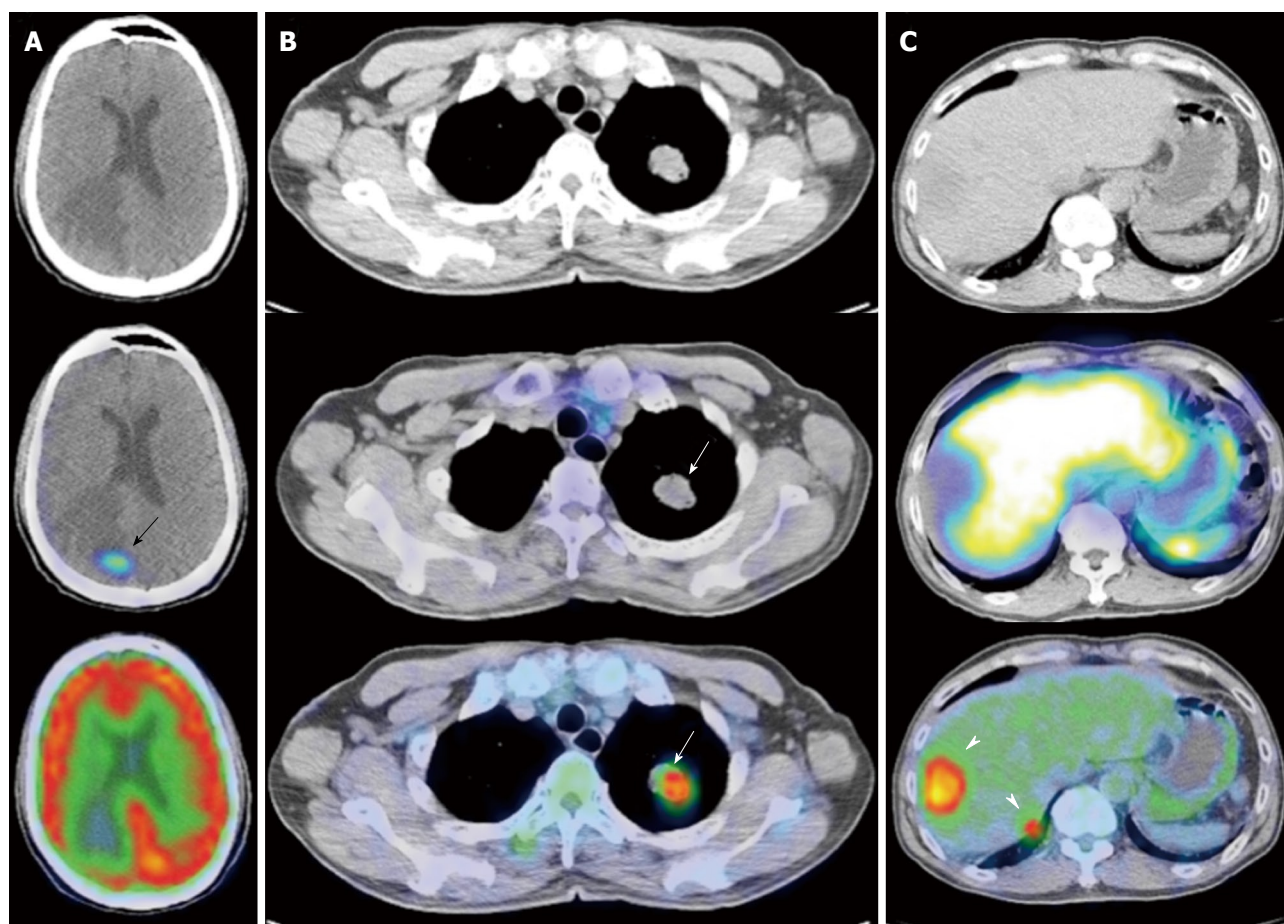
Gallium 68 DOTATATE and Fluorine 18 fluorodeoxyglucose positron emission tomography/computed tomography of a patient with metastatic neuroendocrine carcinoma. A: Axial computed tomography (CT), fused DOTATATE positron emission tomography//CT (PET/CT) and fused fluorodeoxyglucose (FDG) PET/CT images of the brain. There is a focus of moderately increased DOTATATE uptake seen in the right occipital lobe (black arrow) associated with adjacent vasogenic edema, but no definite corresponding FDG uptake is seen; B: Axial CT, fused DOTATATE PET/CT and fused FDG PET/CT images of the thorax. There is an intensely FDG avid mass in the left upper lobe, but no corresponding DOTATATE tracer avidity is seen (white arrows), demonstrating an example of the “flip-flop” phenomenon secondary to tumor dedifferentiation; C: Axial CT, fused DOTATATE PET/CT and fused FDG PET/CT images of the abdomen. Again, there are intensely FDG avid lesions in the right liver lobe (white arrowheads) that do not demonstrate significant DOTATATE uptake, indicative of neuroendocrine tumor dedifferentiation.
